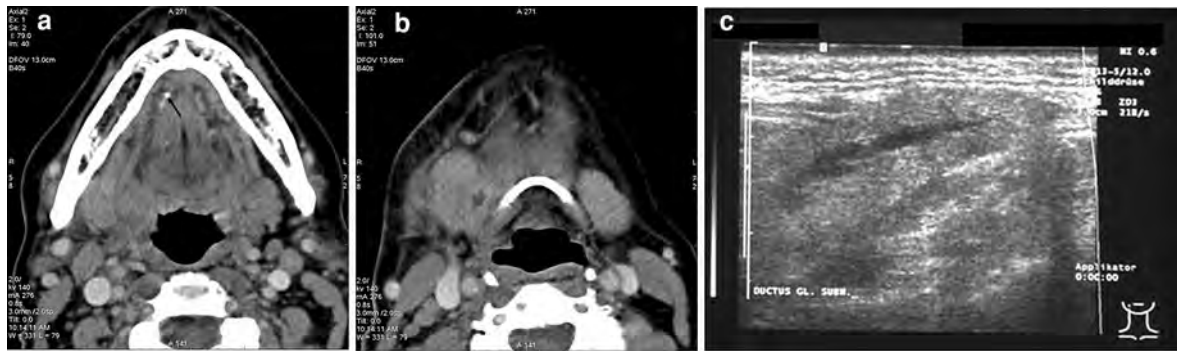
CT of a submandibular abscess due to an obstruction of Wharton's (submandibular) duct by a stone (female, 57 years). In the anterior *right* floor of the mouth, a small stone can be seen at the level of the aperture of the duct (a). The *right* submandibular duct is swollen and contains an abscess
